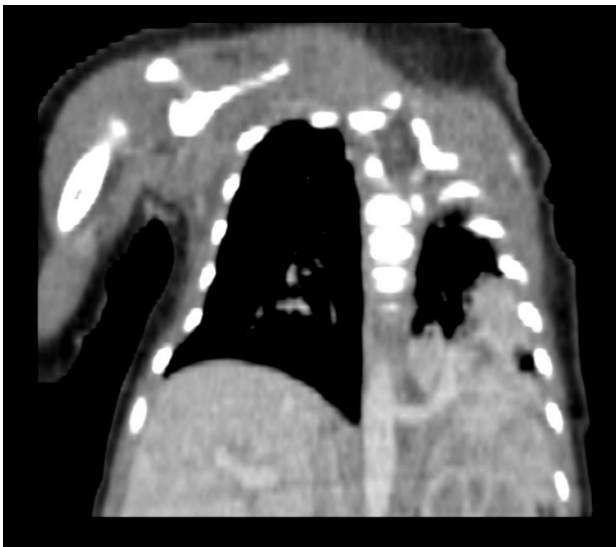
CT scan dated 02/07/2026 in coronal soft tissue window – showing systemic artery arising from descending thoracic vertebra supplying the sequestered lung segment
